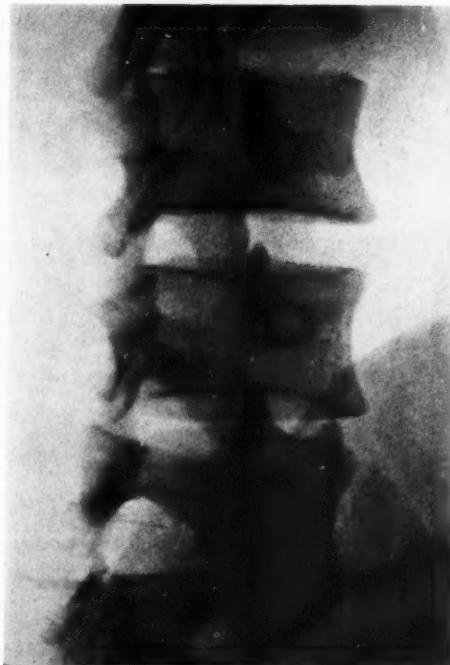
Roentgenogram of the left zygapophyseal joints in a normal spine.
